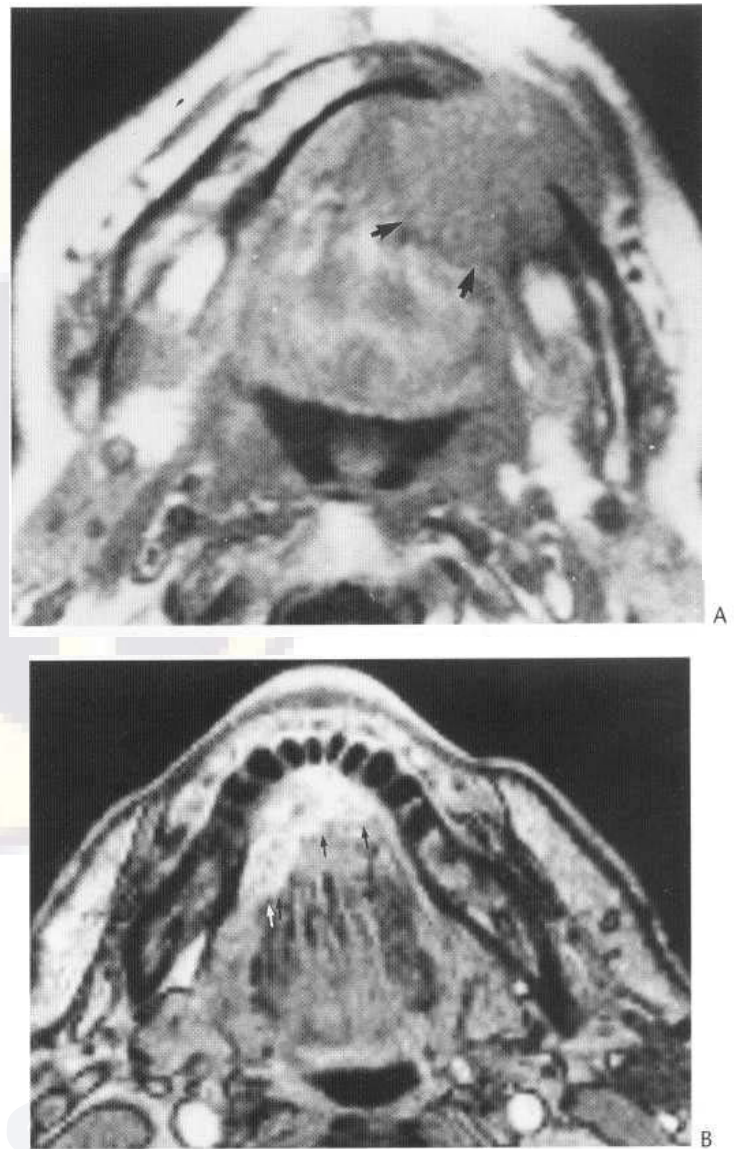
Carcinoma of the floor of the mouth. (A) Axial T₁-weighted MRI showing the lesion as an area of low signal (arrows) extending through the mandible into the buccal sulcus. (B) Gradient-echo FLASH sequence of another case after gadolinium enhancement showing high signal from the tumour (arrows).
